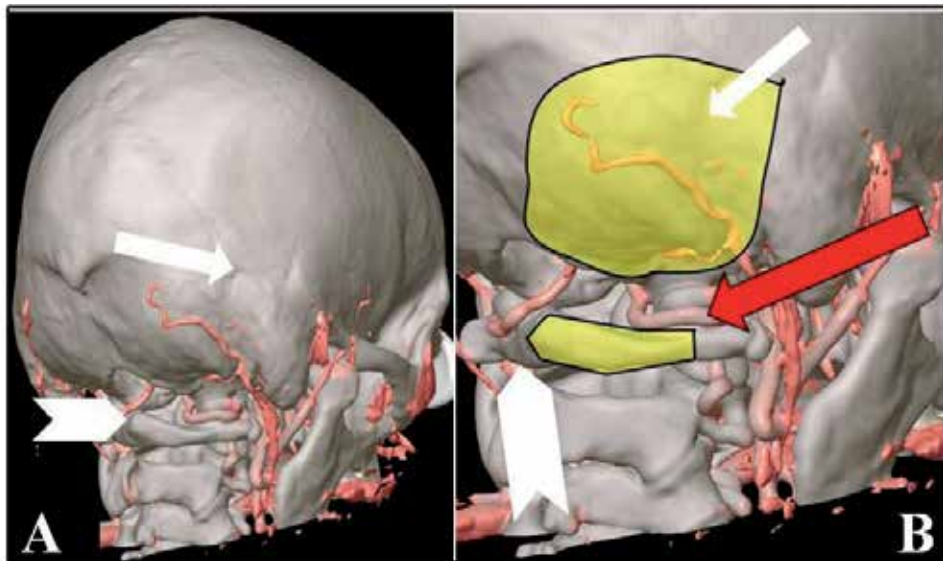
Reconstruction of cranial computed tomography demonstrating the far lateral approach, B is an excerpt of A. Yellow areas highlight the extend of craniotomy and hemilaminectomy of the atlas (open arrow), after mobilization of the vertebral artery (red arrow). The keyhole for suboccipital craniotomy is placed on the asterion (closed white arrow).
